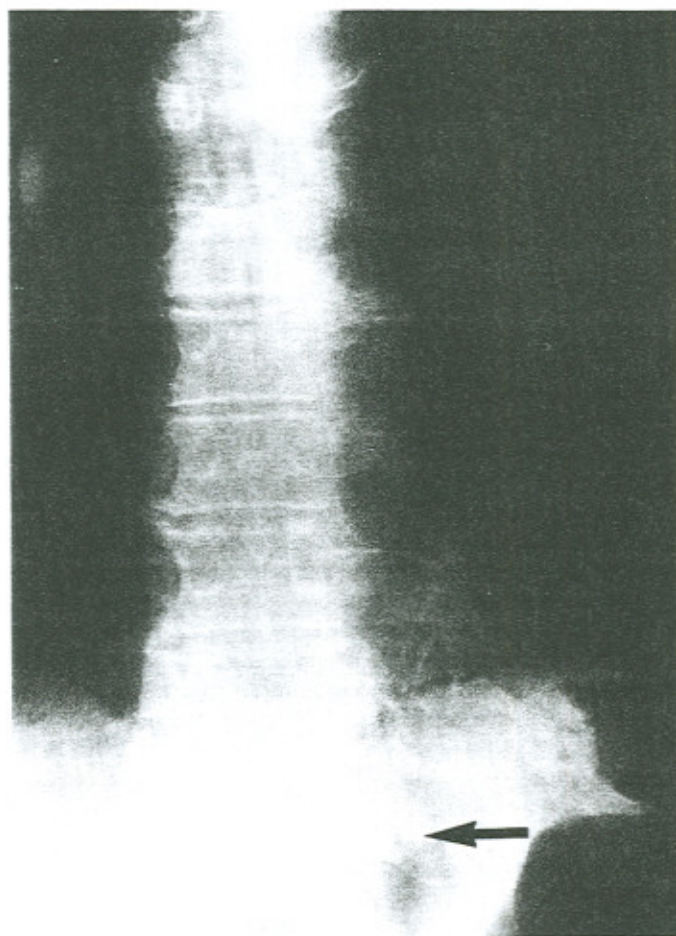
Initial radiographs of case 3 which include the thoracolumbar spine. Severe compression of the T12 body is noted (arrow).
